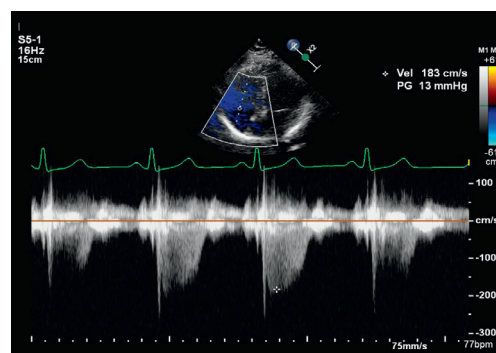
■ RVSP measurement using the TR jet. After optimal alignment of the Doppler beam with the TR jet in the A4CH view, RVSP can be calculated by adding the square of the TR peak velocity in m/s to the RAP. When estimating an RAP of 10 mm Hg, RVSP in this example would be 23 mm Hg. RAP, right atrial pressure; RVSP, right ventricular systolic pressure; TR, tricuspid regurgitation; TR_{PEAK} , peak velocity of TR jet.
